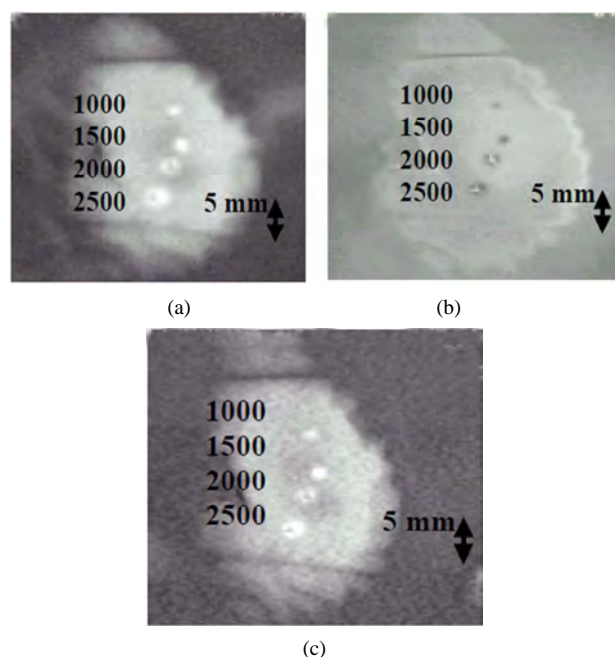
MR images (in a plane perpendicular to the beam) of four lesions (intensities 1000, 1500, 2000 and 2500 W/cm²) in kidney *in vitro* using. (a) T1-weighted FSE; (b) T2-weighted FSE; (c) T1-weighted FSPGR. With intensities above 2000 W/cm² the lesions exhibit boiling activity. The discrimination between boiling and non-boiling lesion is best monitored using T2-W FSE.
